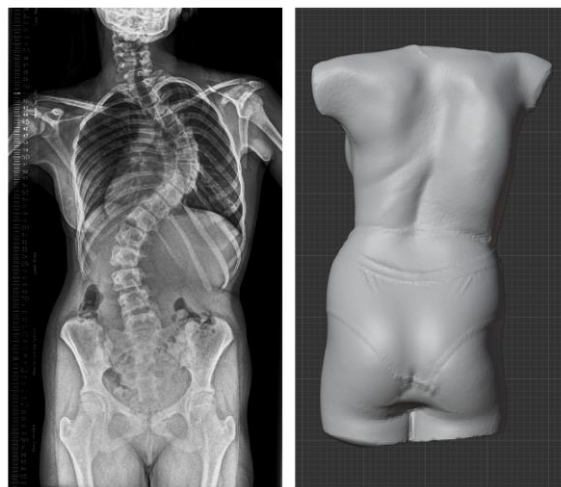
X-ray and corresponding surface topography scan from an AIS patient.
